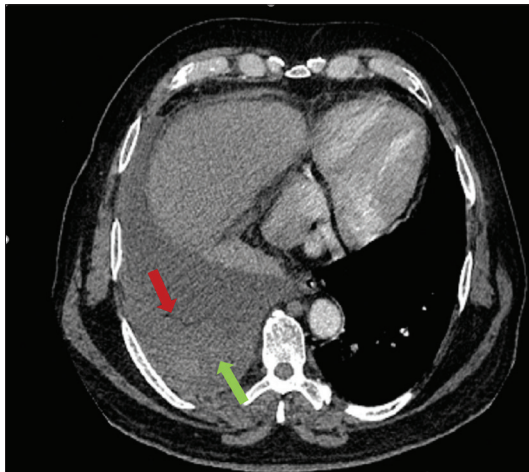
Axial computed tomography image showing an extrapleural hematoma (green arrow) displacing the extrapleural fat (red arrow) anteriorly
